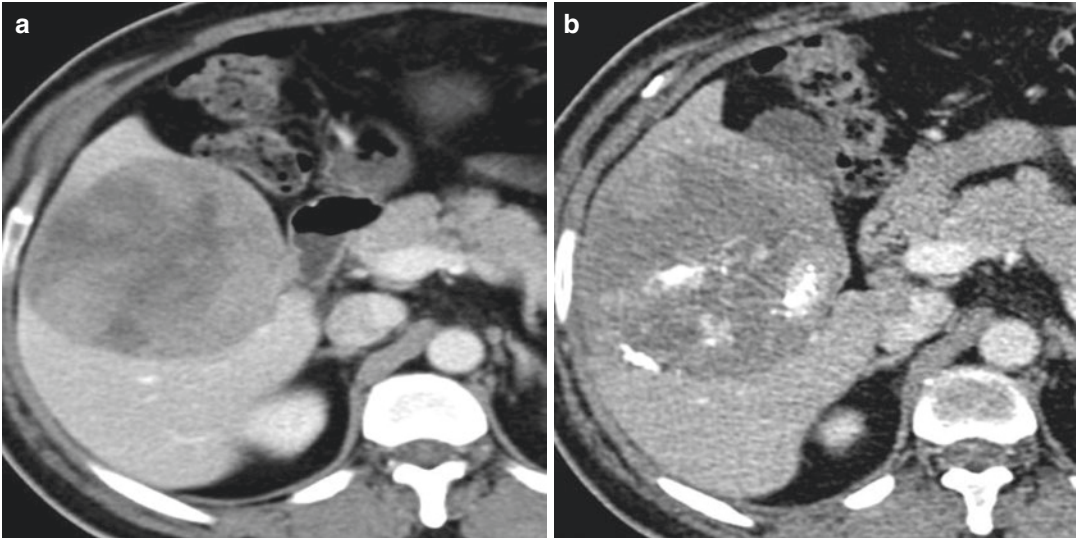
(a) 55 years old male with a known case of right ciliary body malignant melanoma with liver metastases. Pre TACE CT showed a large mass in segment V & VI
